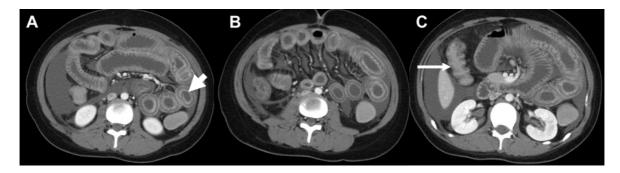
Contrast-enhanced CT scans in a 17-year-old female with multifocal bowel wall thickening; (A) CT scan at the level of lower pole of the kidney shows symmetric and circumferential wall thickening of the jejunum and ileum, there are alternating layers of high and low attenuation within thickened small-bowel wall, demonstrating the "double halo" or target sign (short arrow); (B) CT scans obtained just below level (A) ascending colon reveals bowel wall thickening at the hepatic flexure (arrow in C)
